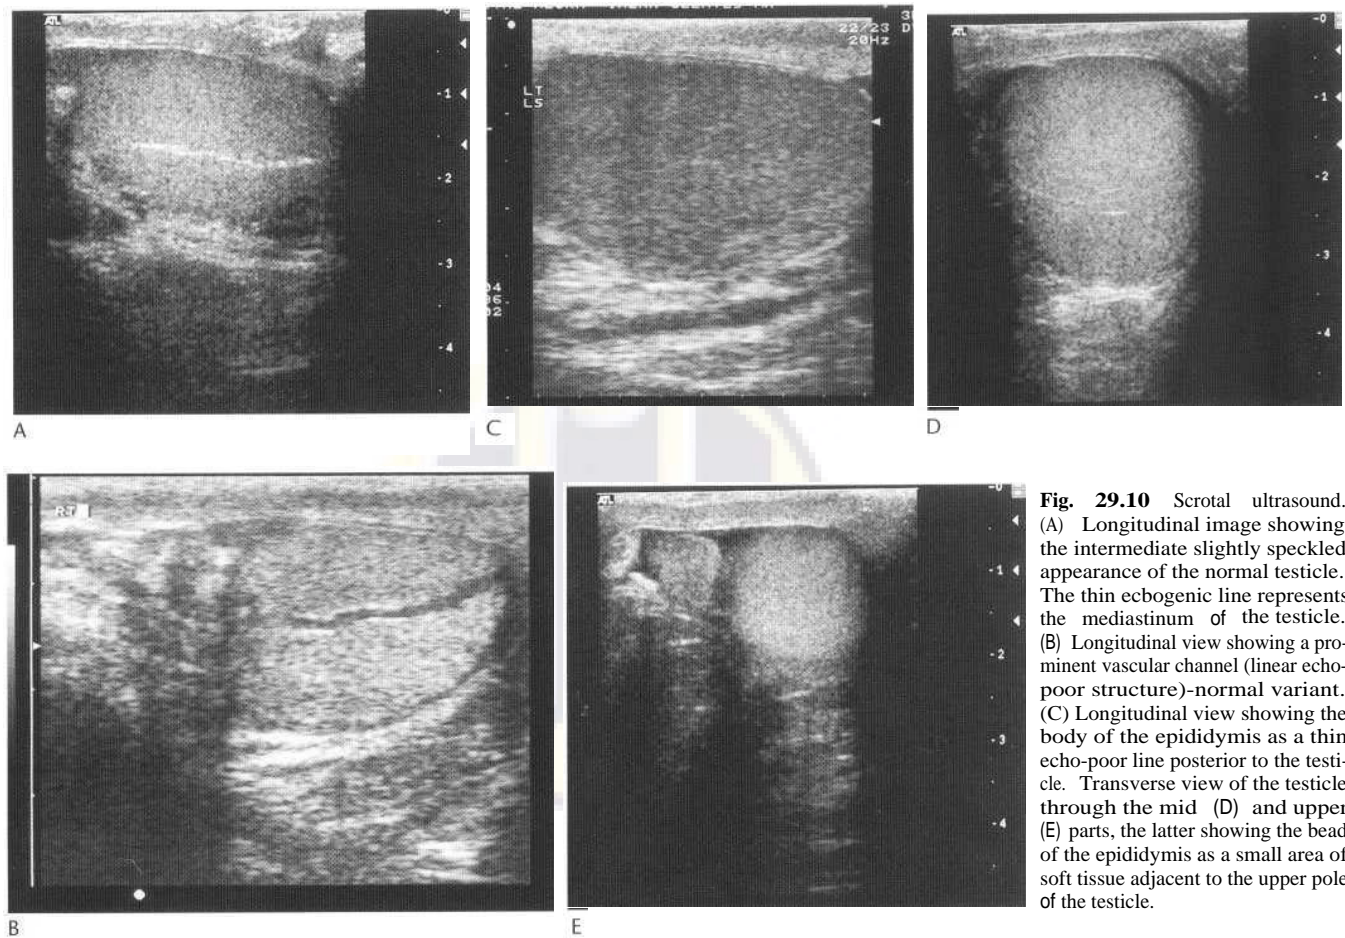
Scrotal ultrasound. (A) Longitudinal image showing the intermediate slightly speckled appearance of the normal testicle. The thin echogenic line represents the mediastinum of the testicle. (B) Longitudinal view showing a prominent vascular channel (linear echo-poor structure)-normal variant. (C) Longitudinal view showing the body of the epididymis as a thin echo-poor line posterior to the testicle. Transverse view of the testicle through the mid (D) and upper (E) parts, the latter showing the bead of the epididymis as a small area of soft tissue adjacent to the upper pole of the testicle.
